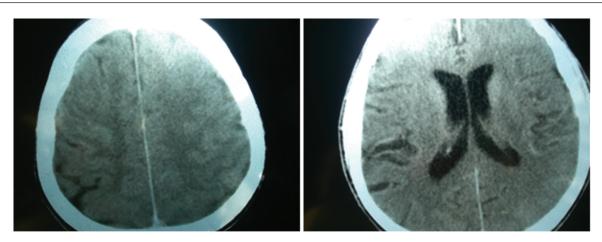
Noncontrast CT (axial) scan immediately following (approximately thirty minutes) after the initial neurological event shows gyriform enhancement and effacent of the sulci in the left cerebral hemispheres (abnormal cortical contrast enhancement and edema in the left hemisphere).
